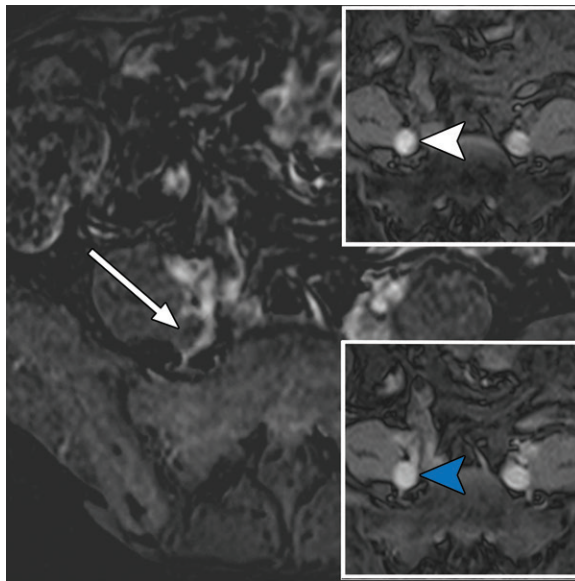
Subtraction inflow artifact in a 50-year-old woman with breast cancer who underwent liver MRI. Axial subtracted T1-weighted delayed phase MR image shows an apparent filling defect in the right common iliac vein (arrow). However, comparison with the precontrast T1-weighted MR image (top inset) shows hyperintense signal (white arrowhead) owing to vascular inflow of unsaturated protons, resulting in artifactual hypointensity (blue arrowhead) when subtracted from the source T1-weighted delayed phase MR image (bottom inset). Vascular inflow artifact is common at the top and bottom of an axial 3D volume.
